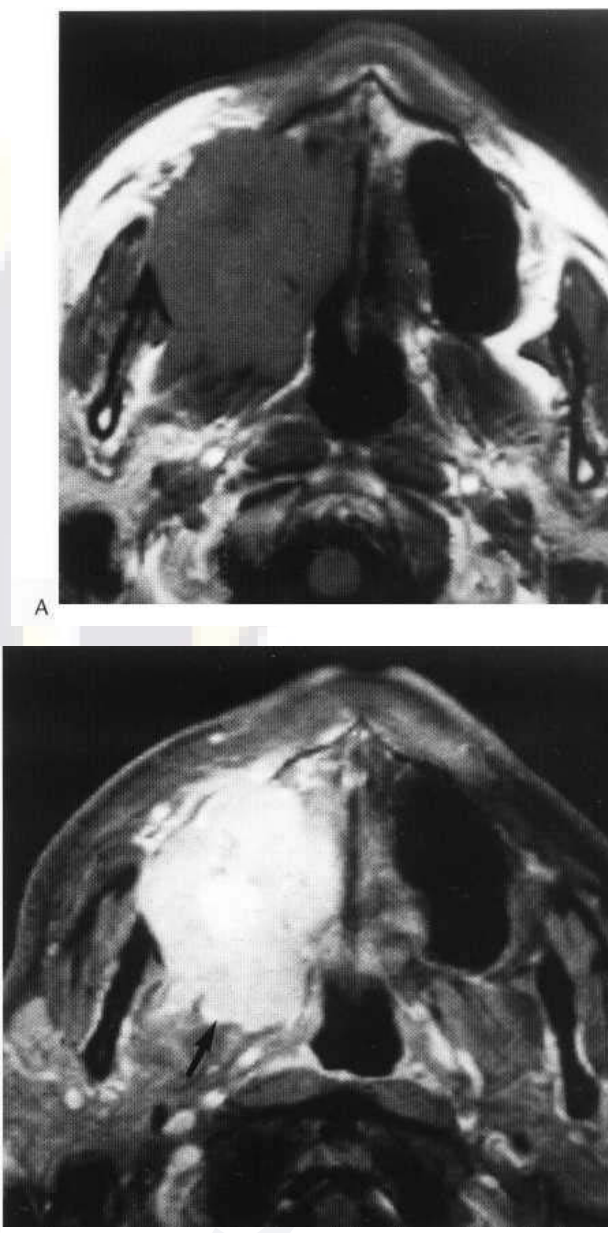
(A) T₁-weighted axial MRI scan of a patient with a maxillary antral carcinoma before gadolinium enhancement. (B) Axial T₁-weighted fat-saturated scan in the same position after gadolinium enhancement. Both scans demonstrate a large mass, which shows enhancement following intravenous gadolinium, filling the right maxillary antrum and extending posteriorly into the infratemporal fossa on the right (arrow).
